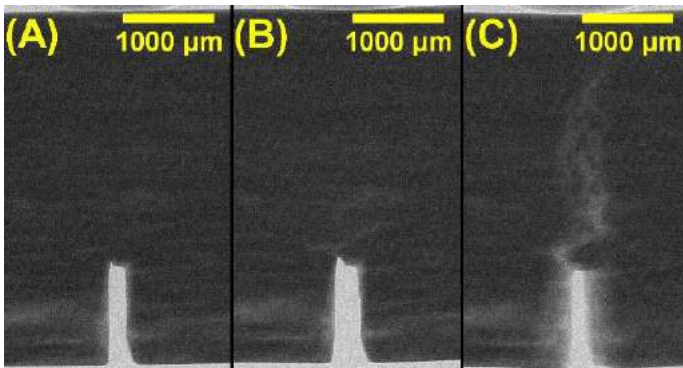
2D x-ray images through bone at (A) start of load, (B) immediately before crack instability, and (C) after instability.
